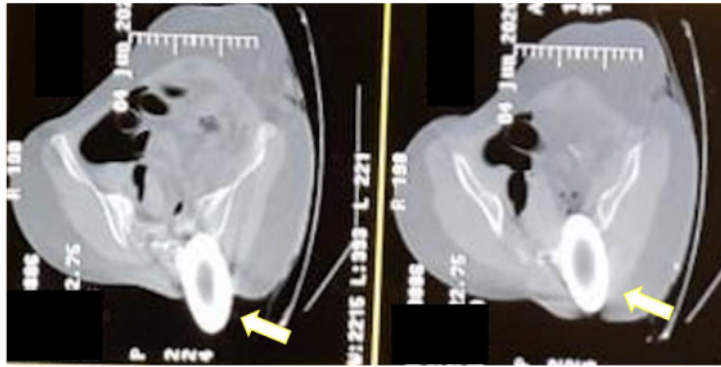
A noncontrast CT scan shows an iron object (arrow) penetrated the right pelvic (axial view).
